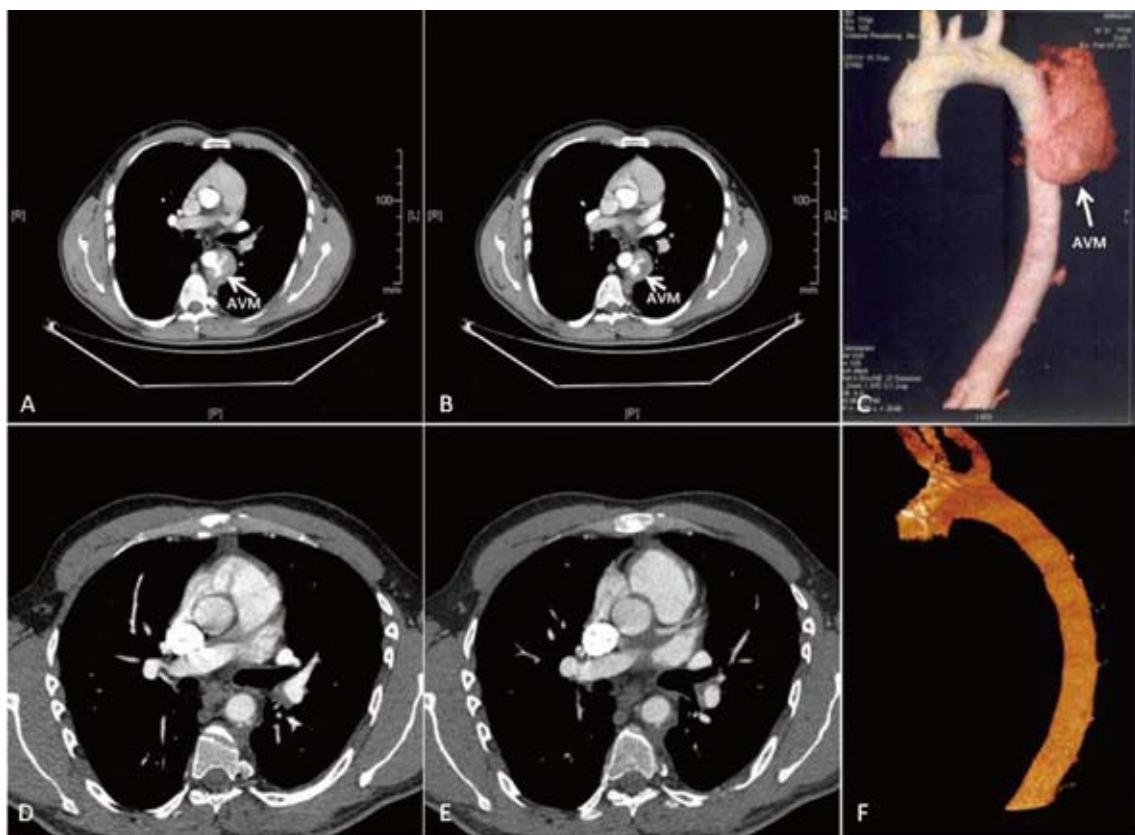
Pre- and postoperative CT angiographic arterial phase scans: Well shaped AVM originating from the aorta with hyper dense areas in preoperative images (A–C) and en bloc of the mass without any residues in postoperative scans (D–F).
